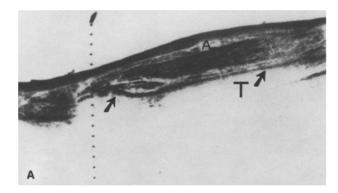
A and B. Case 18, Peripheral aneurysm. 49-year-old woman with history of rheumatic fever and endocarditis presented with sudden calf pain, pulsatile mass, and initially absent distal pulses which subsequently returned. A Sagittal scan through lower extremity shows 2 cm fluid collection (A) which appeared connected to calf vessel. Arrows indicate tibial cortex. B Arteriogram demonstrates small aneurysm in location corresponding to that on ultrasonography (white arrow)
